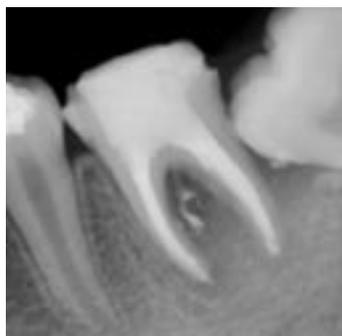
3 month follow-up radiograph shows healing in progress.
